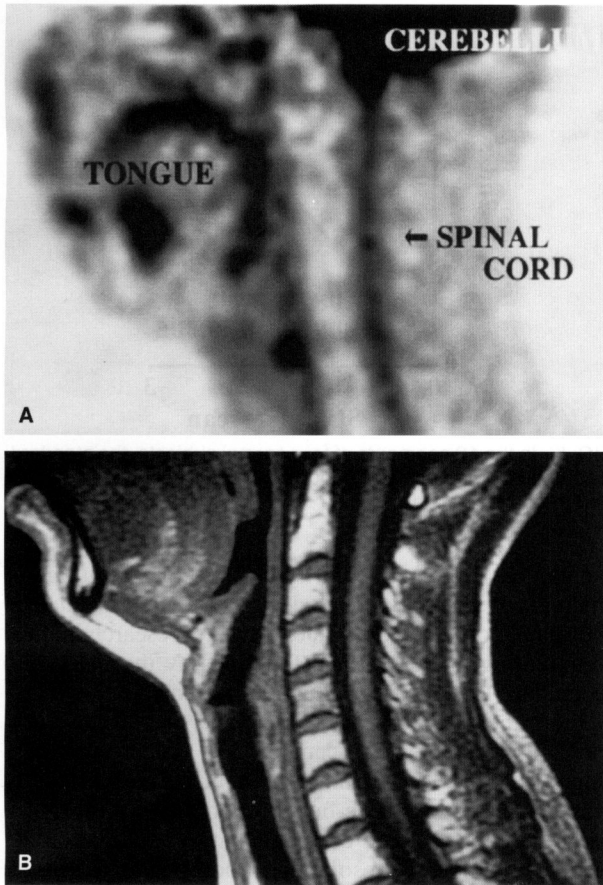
Sagittal FDG-PET (A) and MR (T1-weighted) (B) images of a normal subject (30 years old).
